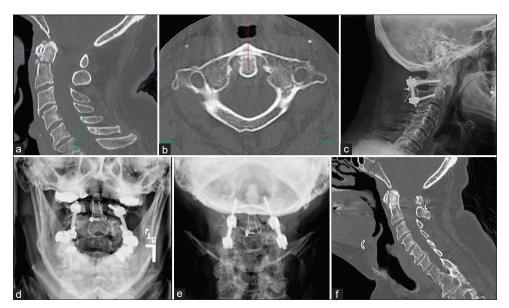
A 76-year-old man presented after a fall from standing with a computed tomography (CT) demonstrating an acute, nondisplaced type II dens fracture (a) with an intact atlas (b). The patient underwent C1/C2 posterior spinal fusion, with good alignment on postoperative lateral (c), open-mouth (d), and anterior-posterior vies (e). A follow-up CT showed interval bony healing of the dens fracture (f)
